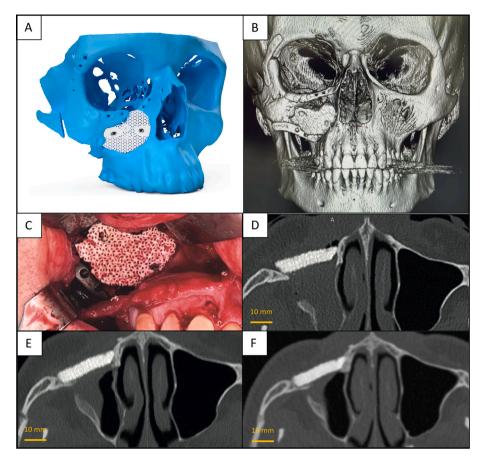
Zygomatic fracture — case 9: (A) preoperative planning (MBCI only); (B) 3D view of the patient facial bones 1-day postoperatively, showing the PSI in place; (C) intraoperative view of the MBCI; (D–F) 1-day, 6-month, and 1-year postoperative CT scans, respectively, showing the MBCI in place and evidence of osteointegration on the edges.
